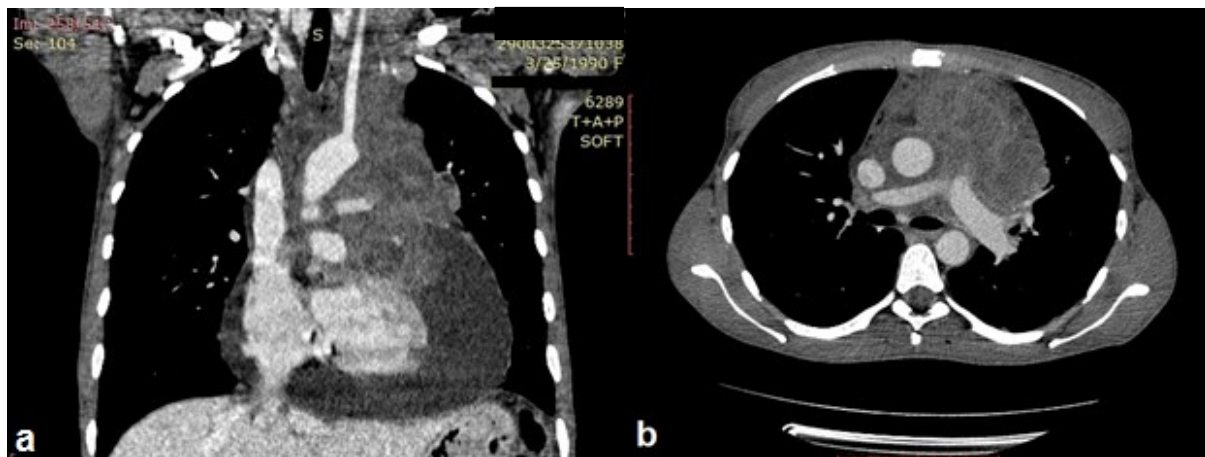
Thoracic CT scan: a) coronal section and b) axial section in a patient with polylobated tumor mass originating in the visceral pericardium and infiltrating the subjacent myocardium with massive pericardial effusion. The tumor surrounded the emergence of the aorta, the aortic arch, left carotid and subclavian arteries and the pulmonary artery.
